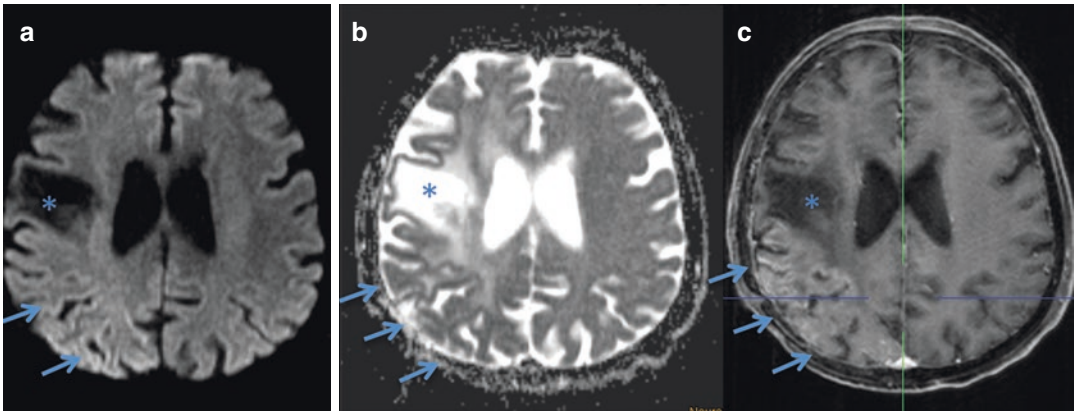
A 65-year-old woman who had radiation therapy following surgery of an oligodendroglioma 25 years ago (a–c: *) presented with headache, neglect, and left-sided epileptic seizures. MRI shows DWI restriction (a, b) and blood–brain barrier disruption (c) of the right-sided
